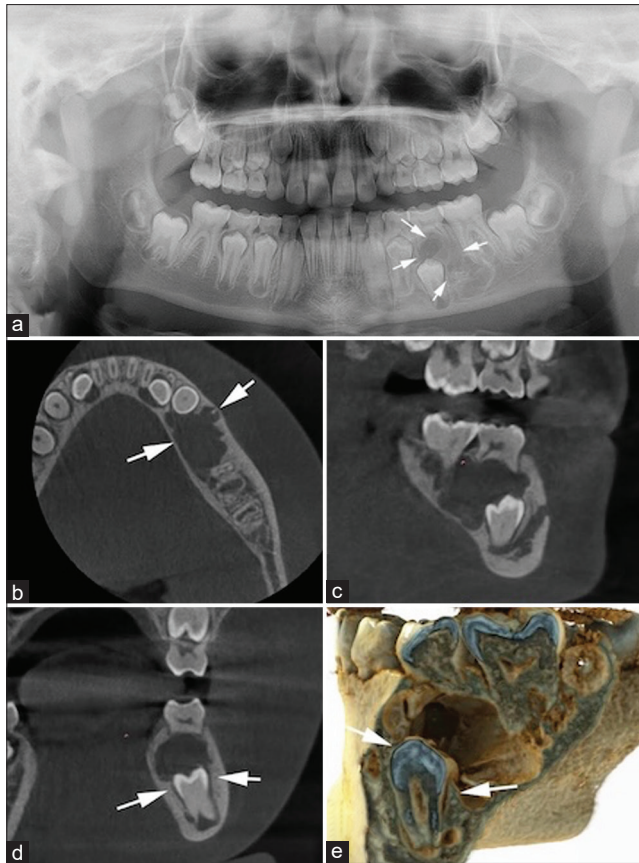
(a) Panoramic radiograph image showing a well-defined periapical unilocular radiolucency (indicated by arrows) associated with the roots of the left mandibular second deciduous molar and the coronal portion of the unerupted second premolar. Cone-beam computed tomography scans presenting in (b) axial reconstruction an osteolytic lesion with thinning of the lingual plate and disruption of the buccal plate of the left mandible body (indicated by arrows). (c) Sagittal reconstruction showing the osteolytic lesion associated with resorption of the deciduous tooth root. (d and e) Coronal and three-dimensional reconstructions (realistic filter – e-Vol DX, CDT Software, São José, SP, Brazil) exhibiting the lesion extension beyond the enamel-cementum junction of the unerupted tooth (indicated by arrows)
